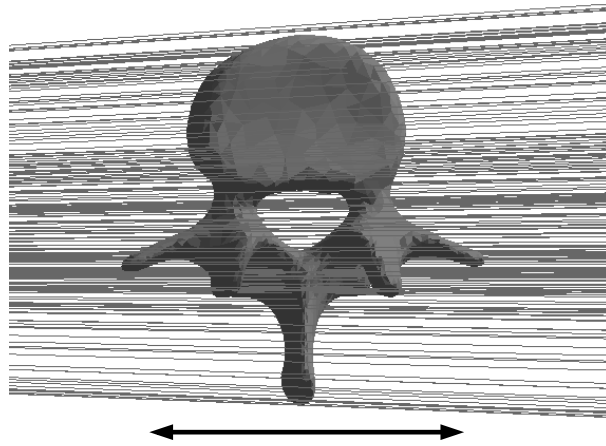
If only a single X-ray image is acquired there is no stable solution for the translation in the indicated direction.
